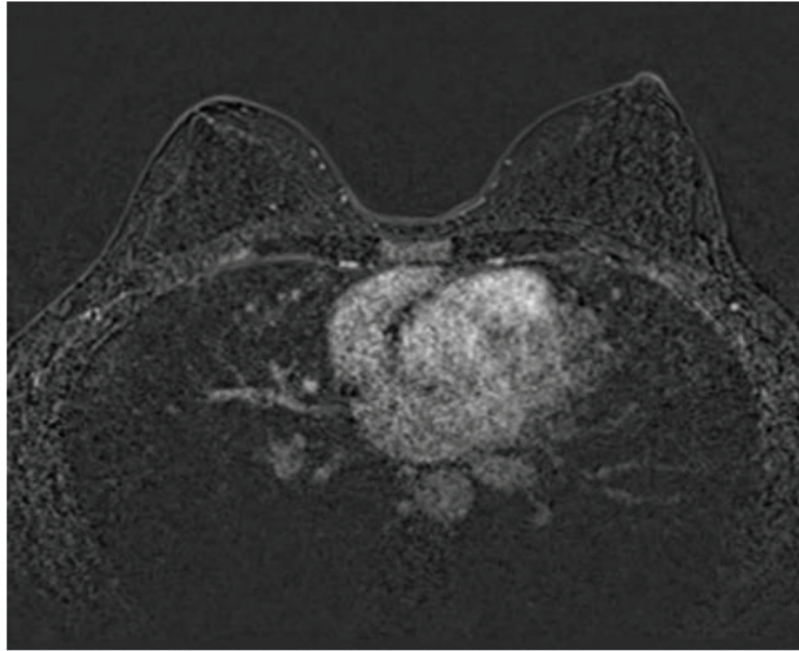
MRI post NAC – dynamic 1 – complete imaging and pathological response after neoadjuvant chemotherapy.
